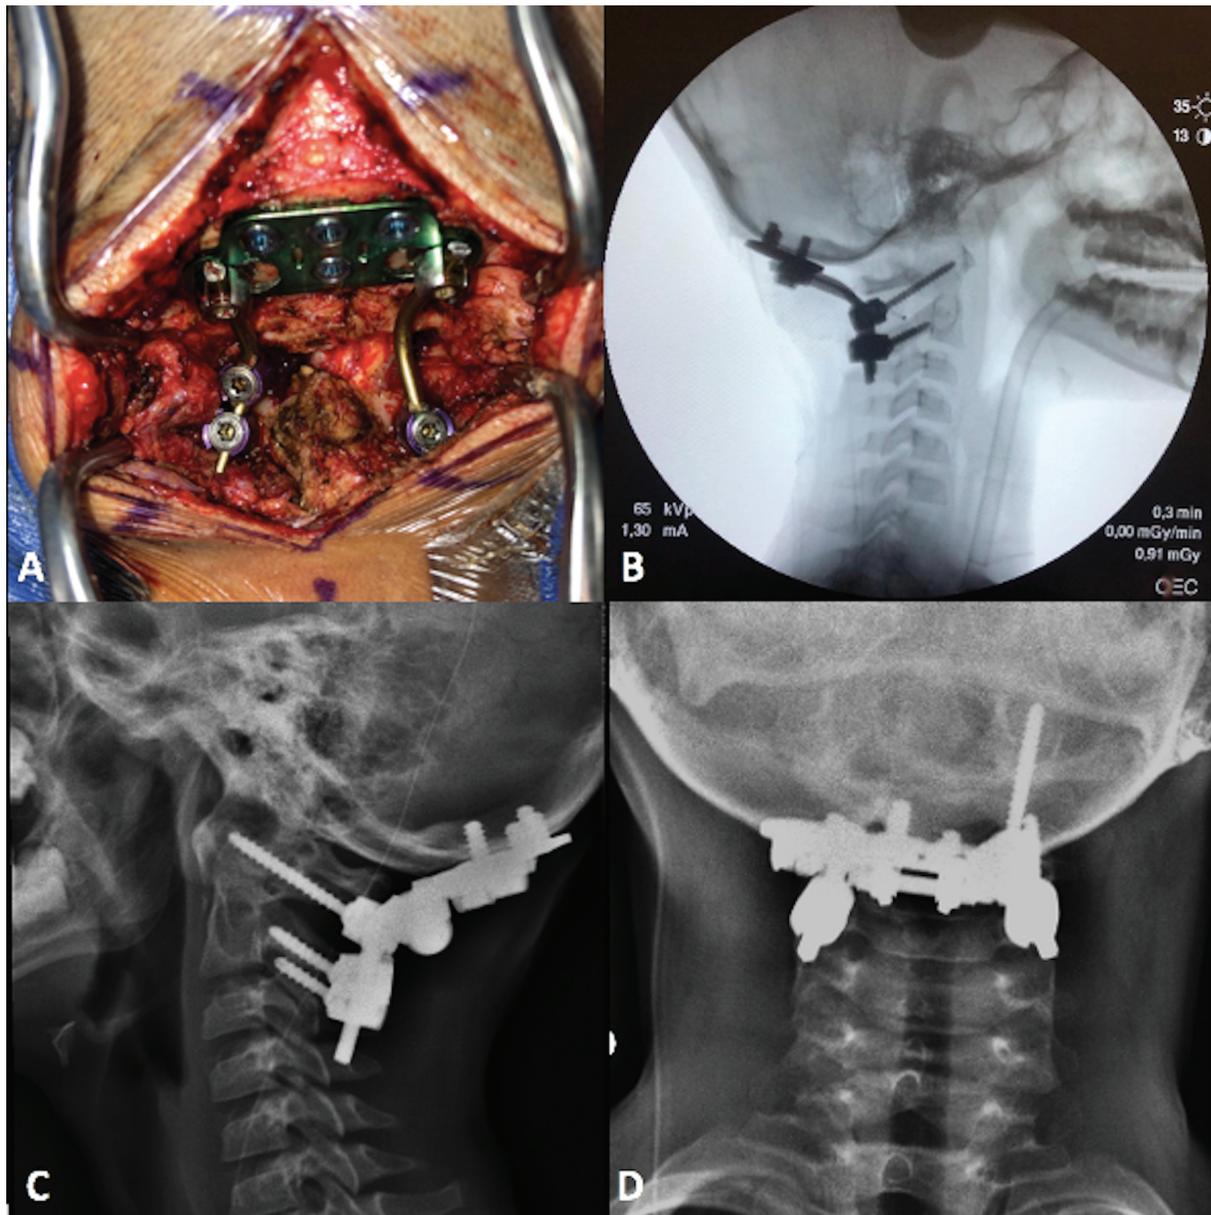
(A) Intraoperative picture of the occipital plate and bilateral polyaxial pars screws at C2, and a unilateral left C1 lateral mass screw. (B) Lateral radioscopy confirms adequate positioning of the construction. (C and D) Follow-up X-rays with adequate screws positioning and fusion.
